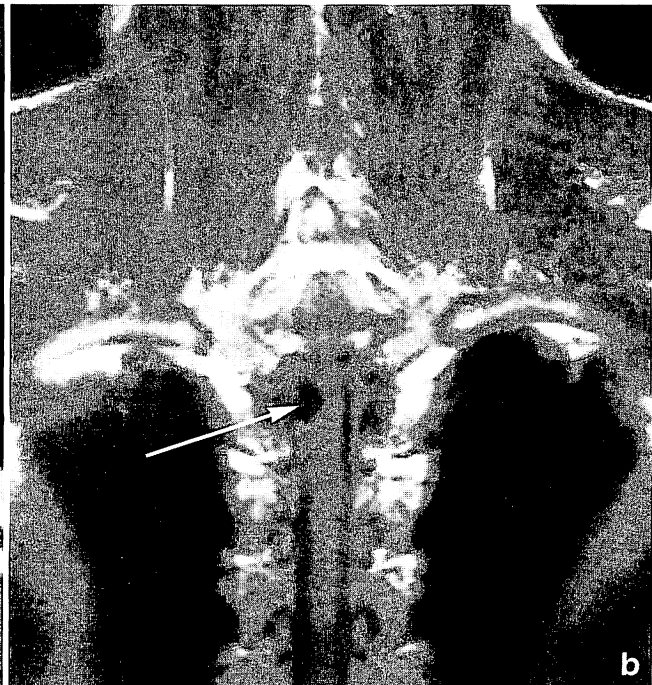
A 52-year-old male with ossification of the yellow ligaments (OYL) at Th2 level. a) CT scan reveals the large OYL (arrowheads). b) and c) Coronal and axial T1-weighted SE images reveal a low signal intensity mass shadow (arrow or arrowhead), which resembles an extramedullary tumor
